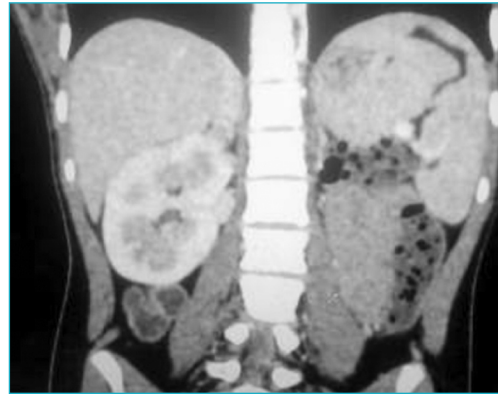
A coronal section of computed tomography intravenous pyelography showing absent left kidney.
